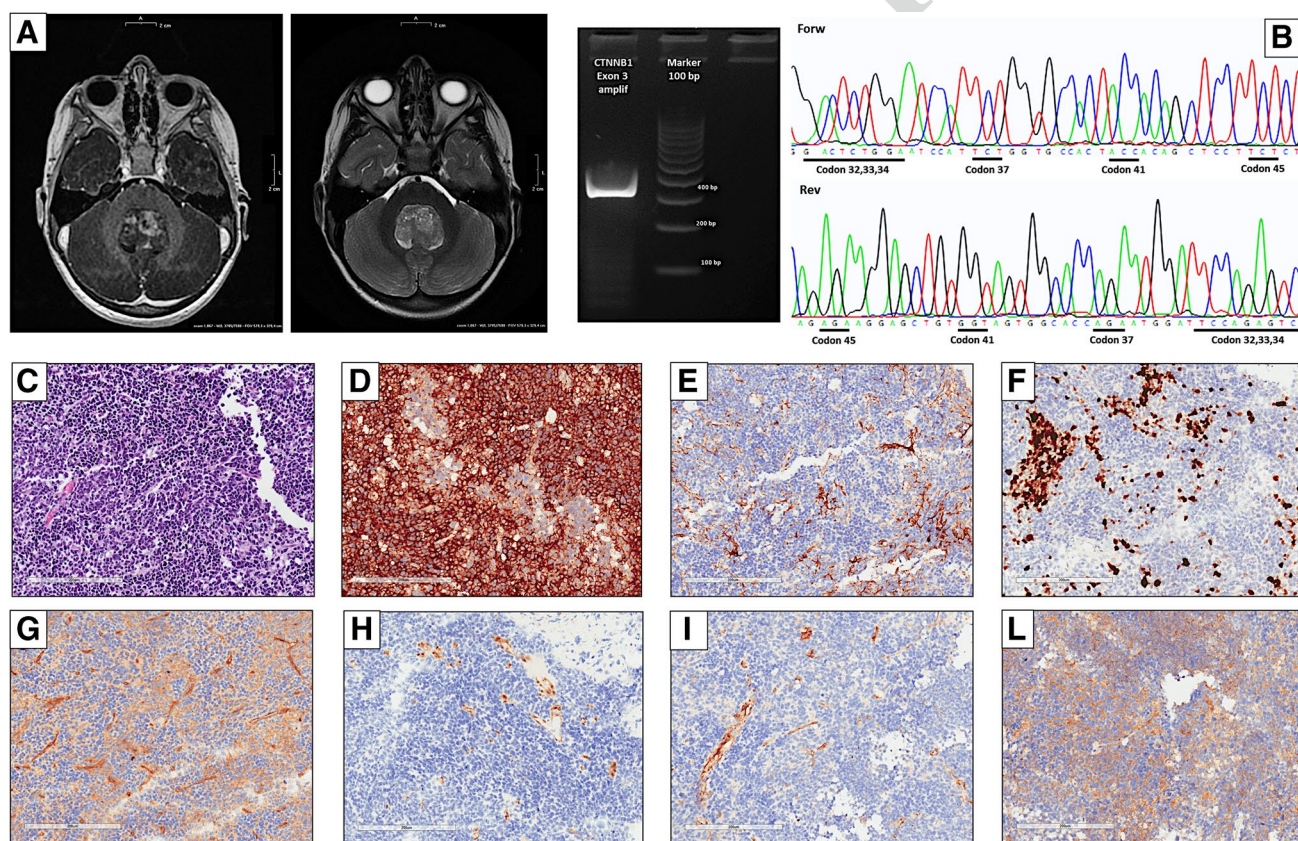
AQ4 A MRI appearances of a solid lesion of 3 × 3 × 5 cm in size in a 4-year-old child on transverse contrast-enhanced T1-weighted (left) and T2-weighted (right) images, evidencing inhomogeneous contrast enhancement adhered to the cerebellar vermis in the fourth ventricle, typical location of MDB. B PCR amplification of the exon 3 of *CTNNB1* and bidirectional Sanger sequence traces do not show mutations; codons most commonly involved in tumorigenesis of MDB as 32, 33, 34, 37, 41, and 45 are highlighted. C–L Representative
